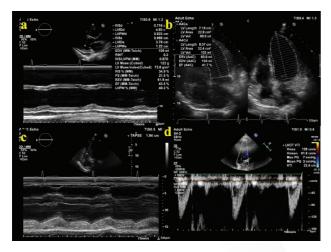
Echocardiography evaluation on day-11 showed: a. non dilated LV; b. improved LVEF of 42%; c. improved TAPSE of 19 mm; d. improved stroke volume with LVOT VTI of 22 cm
